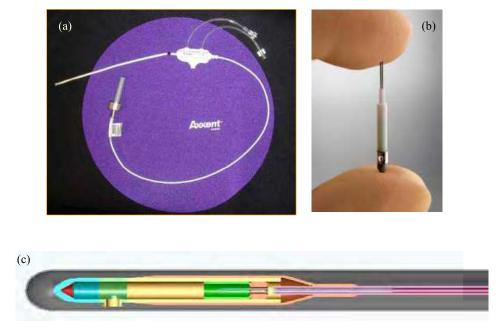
(a) Axxent Xoft miniature x-ray source inserted into to a flexible cooling catheter; (b) The actual size of the miniature x-ray source; (c) The x-ray source tip detail including miniature x-ray tube and HV cable.
